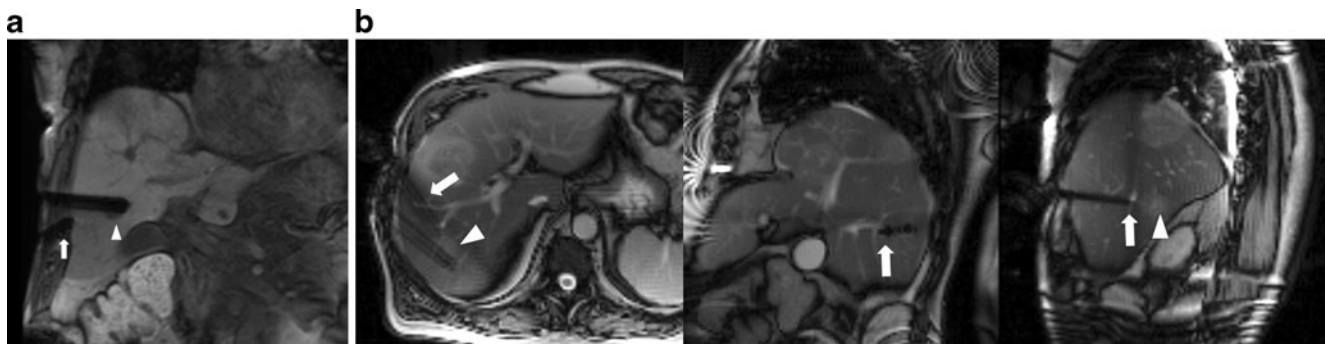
a Coronal slice of a predominantly T1-weighted steady-state free precession sequence of the same patient. A second applicator (*arrow*) is directed to the same tumour and will be placed caudal to the first applicator. A part of the tumour can be seen caudal to the tip of the first applicator (*arrowhead*). b A predominantly T2-weighted steady-state free
